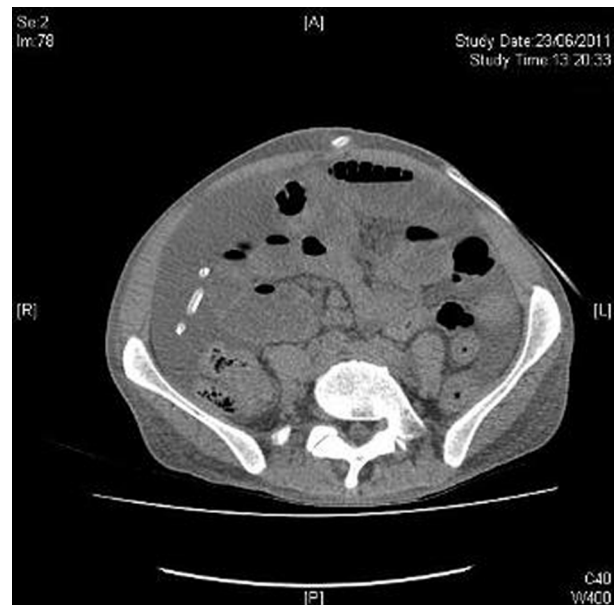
Non-contrast CT image showing multiple bowel loops with thickened peritoneum.
